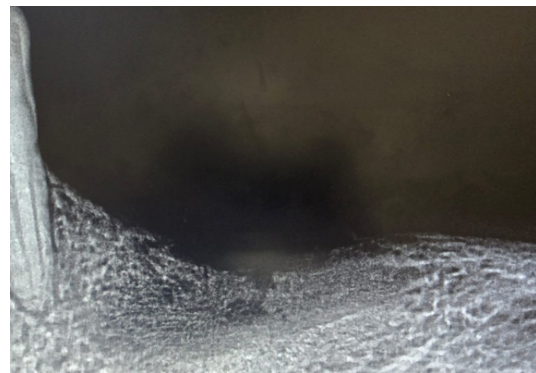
Follow-up periapical X-ray.
